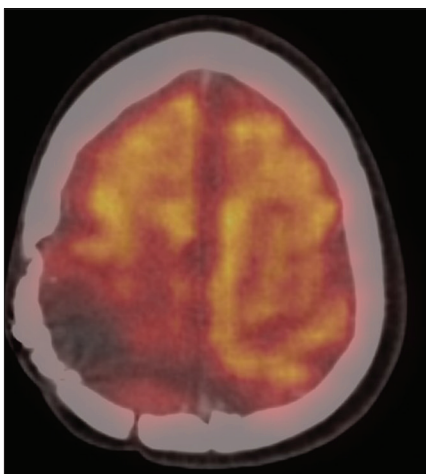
$^{18}\text{F}$ -FDG-fused PET/CT brain image showing no recurrence.  $^{18}\text{F}$ -FDG:  $^{18}\text{F}$ -fluorodeoxyglucose, PET/CT: Positron emission tomography/ computed tomography
